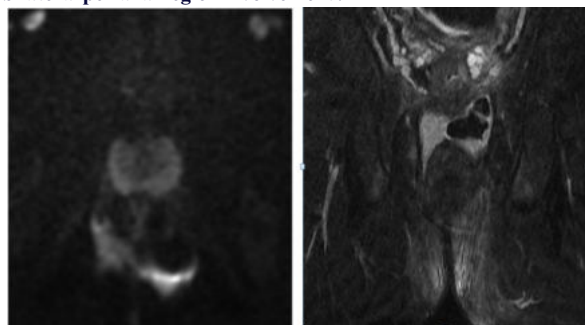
Horseshoe abscess showing diffusion restriction on DWI.
